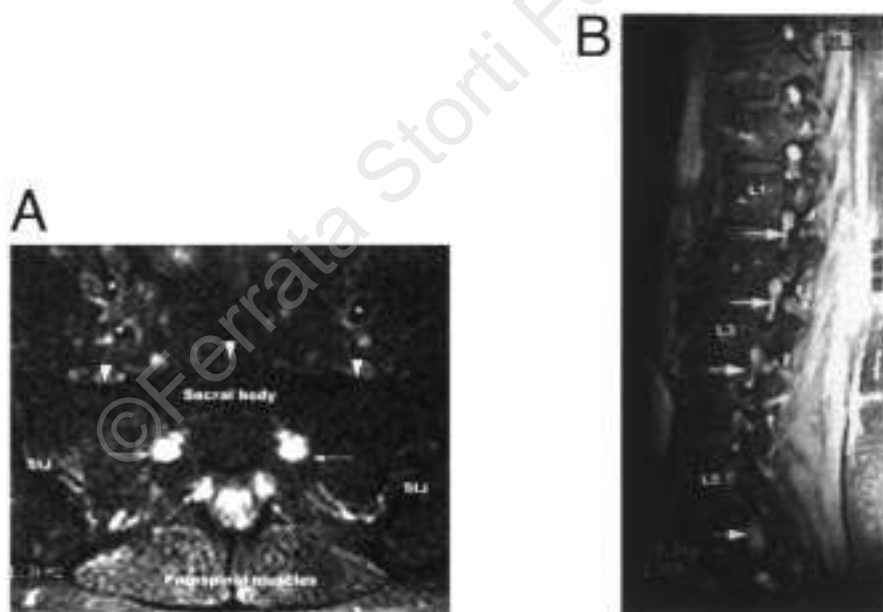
A. T2-weighted fast spin echo (FSE) axial scan of the lumbar spine shows hyperintense signals surrounding the cauda equina (arrows). SIJ denotes the sacral-iliac joints. Arrowheads outline the anterior surface of the sacrum and *denotes the iliac vessels. B. Post-contrast T1-weighted SE sagittal scan of the lumbar spine confirms leptomeningeal enhancement around the nerve roots (arrows) exiting from the neural foramina.
